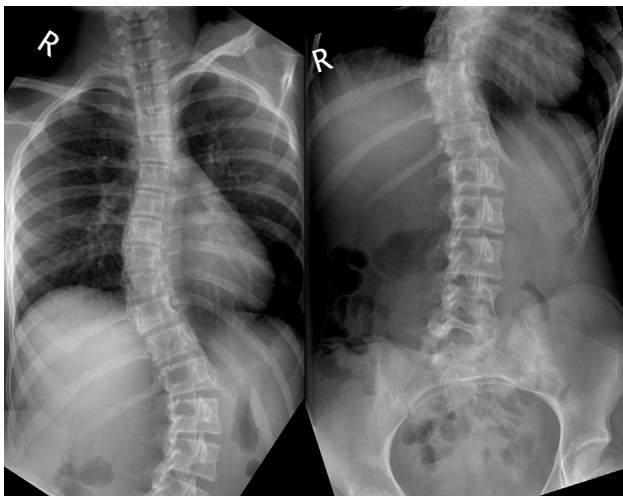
Preoperative bending radiographs of the patient in Fig. 5.
